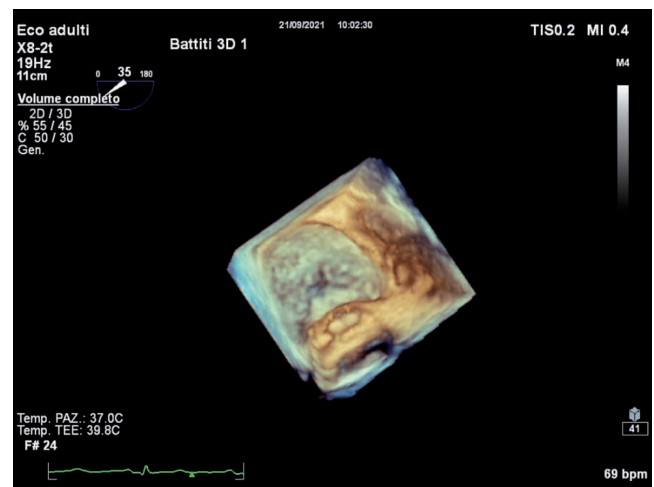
Real-time 3D transesophageal echocardiography. Aortic pseudoaneurysm.
